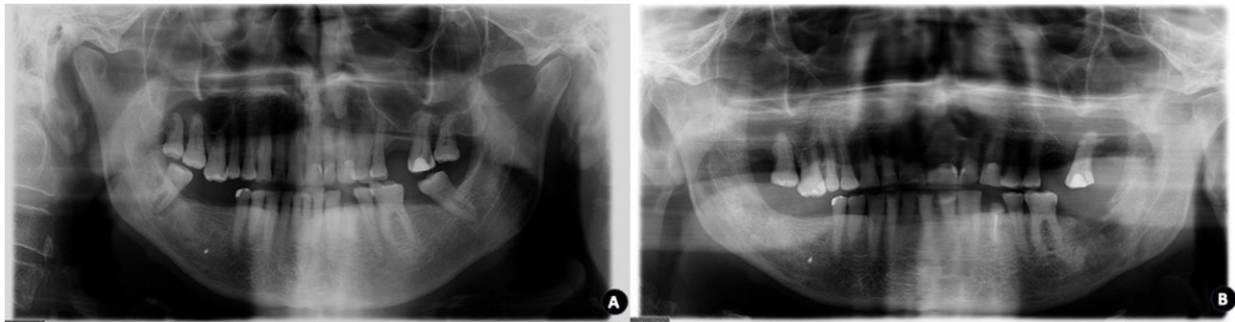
Radiographic condition of the ORN lesion in Patient # 3 at baseline (A) and at the 90th day after application of i-PRF (B).
